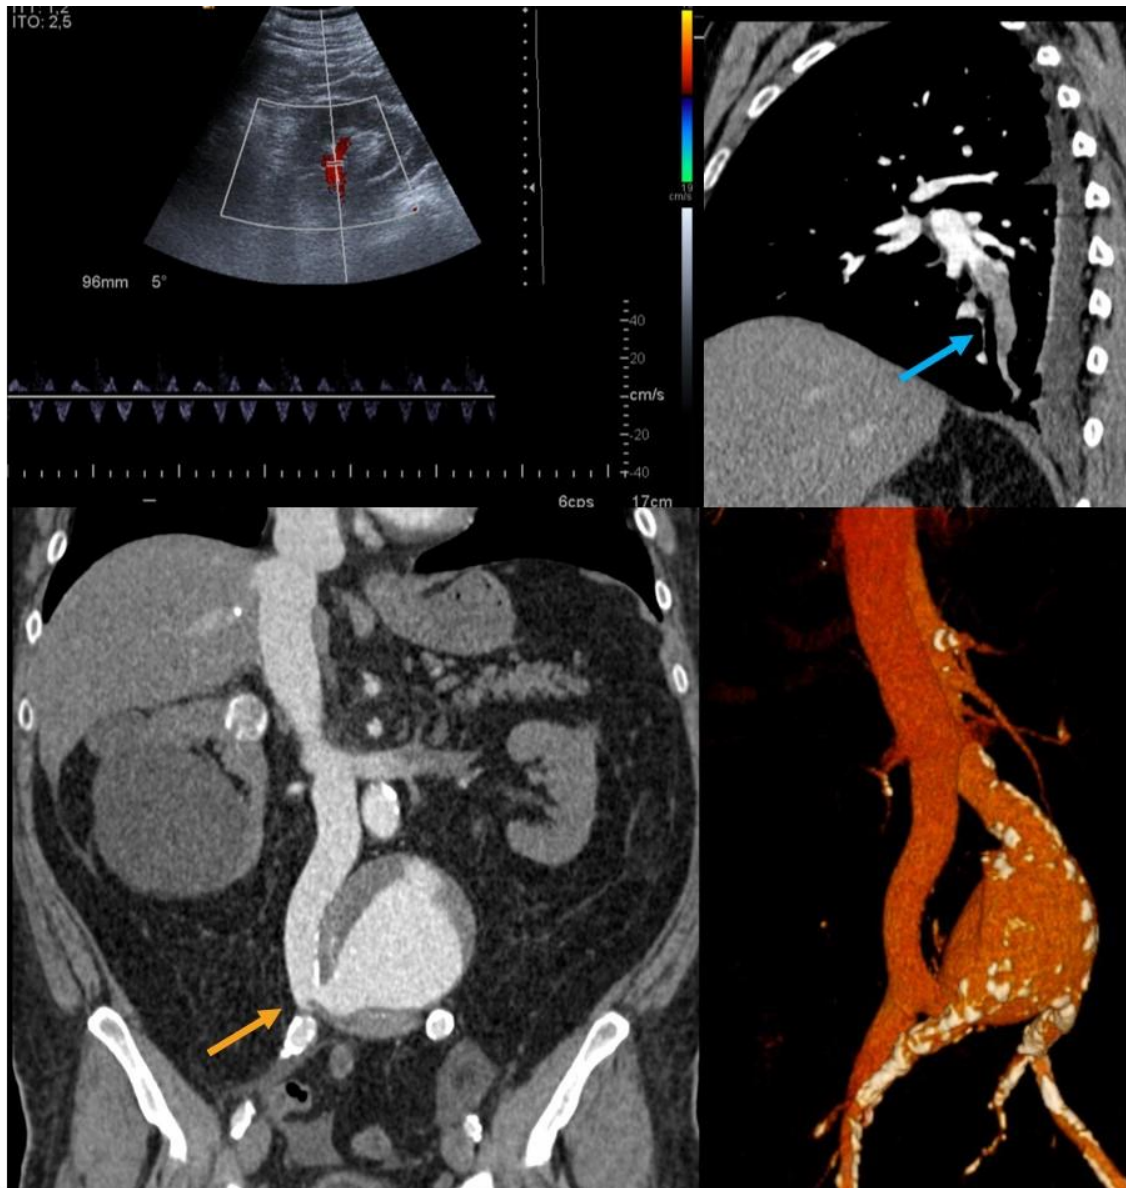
A. Pulsed Doppler shows pulsatile flow in left renal vein. B. Segmental pulmonary embolism on contrast-enhanced computed tomography (CT) (blue arrow). C. Aortoiliac fistula with direct communication between the aorta and the vein (yellow arrow). D. 3-D CT reconstruction.
